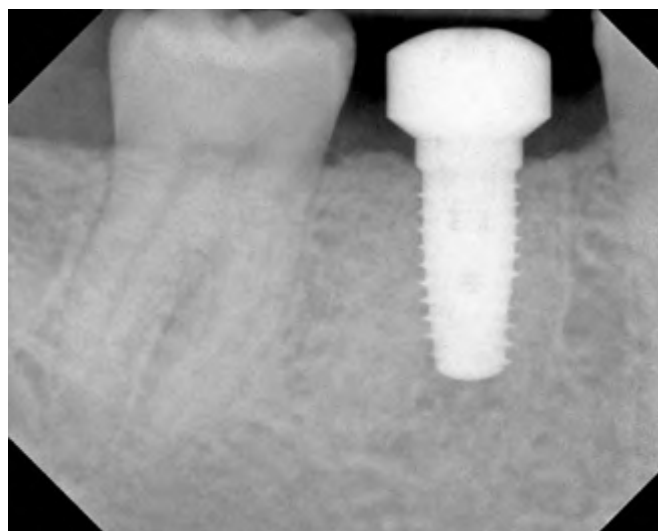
This radiograph was taken just prior to patient discharge, after implant placement. A 7.5-mm-diameter healing abutment, with a 4-mm collar height was placed. This was consistent with the cervical diameter of a mandibular first molar. The healing abutment was completely seated onto the implant restorative platform.
